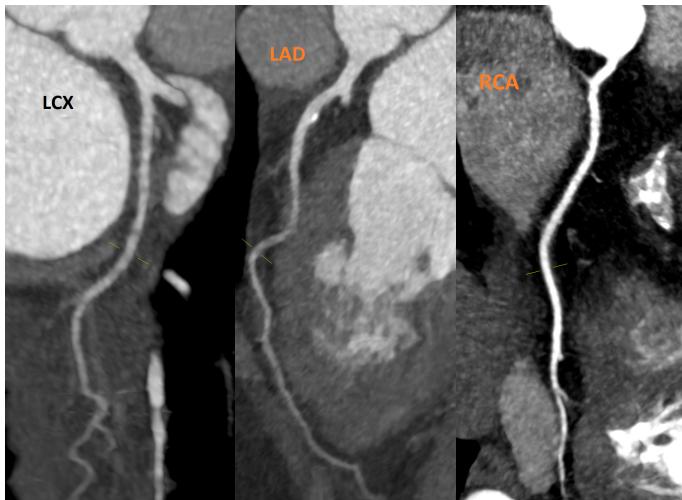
40 ml of contrast media is injected at a rate of 5.5 ml/sec. A Turbo Flash, high-pitch, single beat sub-second acquisition is performed at a CT dose index of 1.62 mGy and a total DLP of 89 mGy*cm. The scan length is 150.9 mm, covered in 0.3 sec scan time. Siemens CARE Dose 4D and CARD kV solutions allow performing the study with low contrast medium volume at 70 kV and 405 mAs, reducing the total effective dose to 1.24 mSv (with a conversion factor of 0.014).
